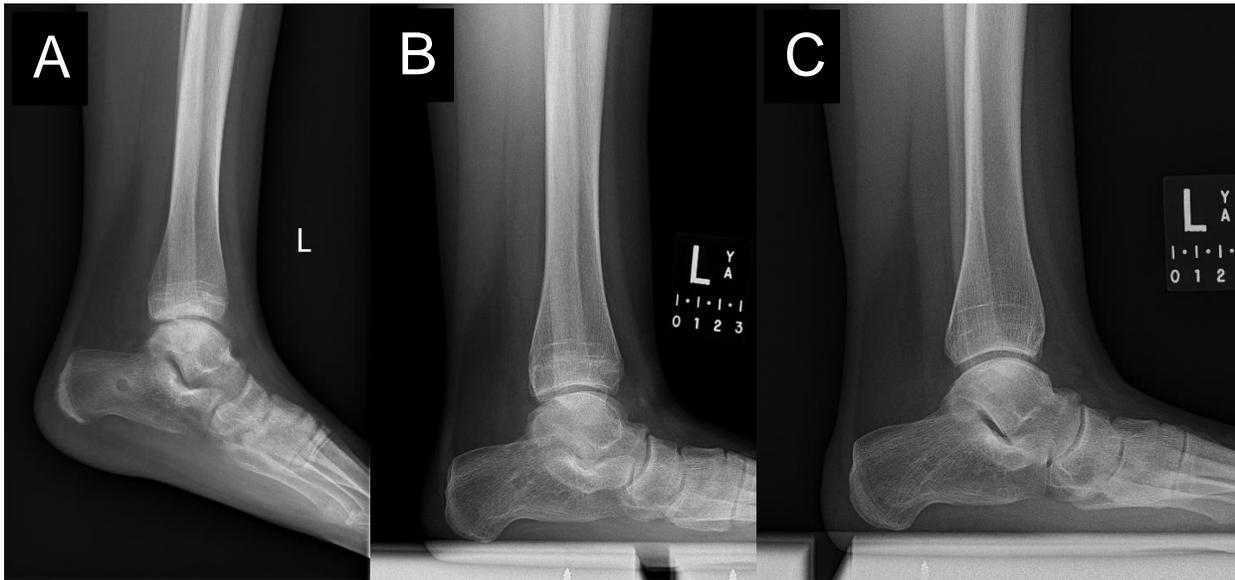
A) 1 month B) 14 month and C) 24-month post-operative plain film radiographs showing the healing progress to the calcaneal harvest site. Patient had no post-op pain at the harvest site. No backfill was used.
